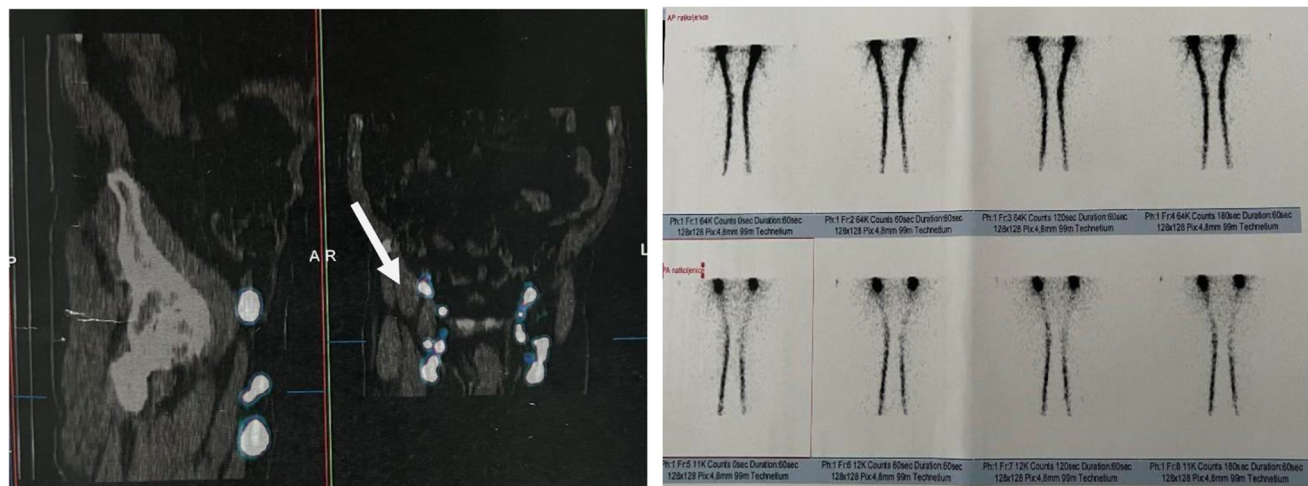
A,B: Lymphoscintigraphy of the lower extremities, pelvis, and abdomen. The arrow points to normal bilateral lymph drainage with developed collaterals in the area of the right leg, without signs of tissue congestion or lymph extravasation.
